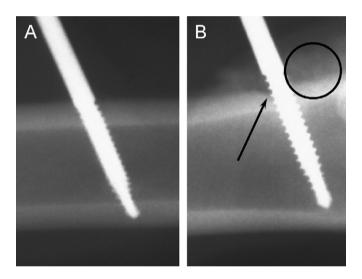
X-ray examples of implanted pins. (A) A non-infected pin site, after electric current application for 21 days and (B) an infected control pin site, in the absence of electric current application. The inflammatory reaction of the periosteum is encircled and the osteolytic zone in the cortex is indicated by the arrow.
